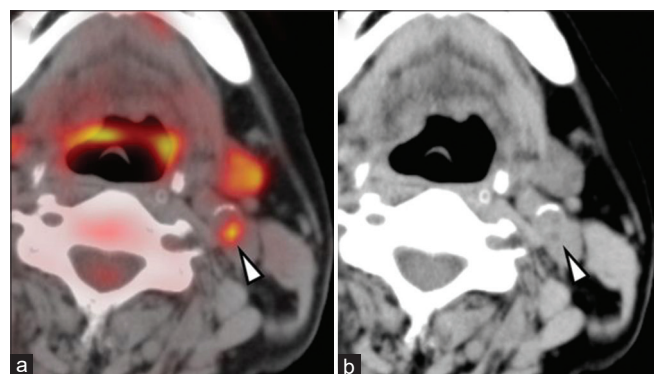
Transaxial ^{18}F -FDG positron emission tomography/computed tomography image (a) demonstrating focal avid ^{18}F -FDG uptake in the carotid plaque (arrowhead). Corresponding axial computed tomography image (b) showing a low attenuating plaque in the left carotid artery (arrowhead)
